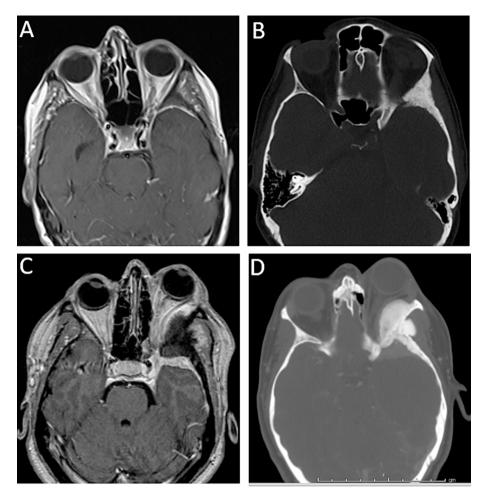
Preoperative CT and MRI images showing our definition of WHO1 SOM as local when there was no invasion of the SOF, OA and CS (A-B) and as "extended" when tumor was localized into one of these critical structures (C-D). (C) shows CS involvement.
